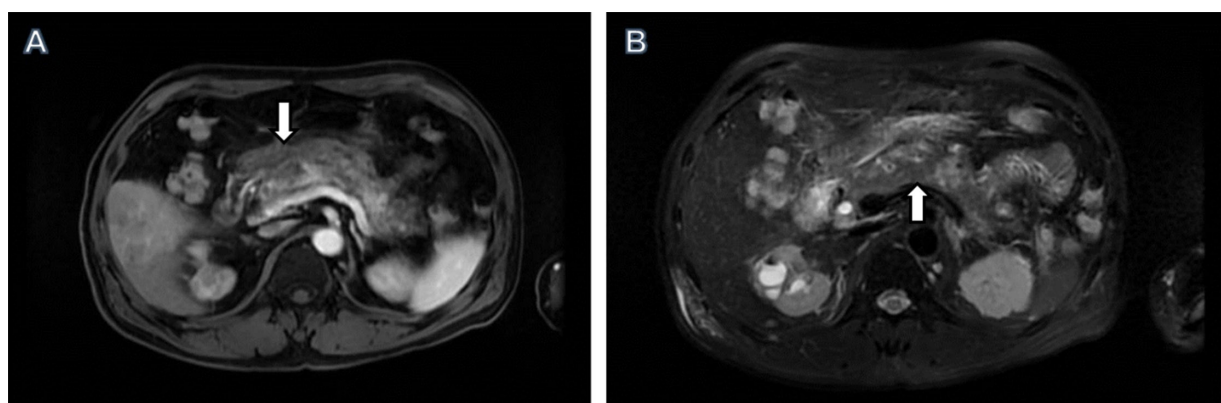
A-B, MRI images of a 53-year-old patient with necrotizing AP (arrow).
